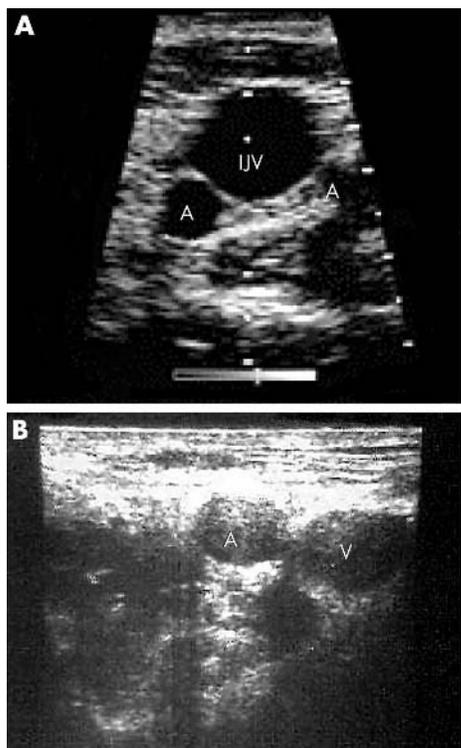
(a) Demonstration of Vascular Anatomy by Ultrasonography: Internal Jugular Vein (IJV) demonstrated above carotid artery (A) bifurcation. (b) Femoral Artery (A) and Femoral Vein (V).
